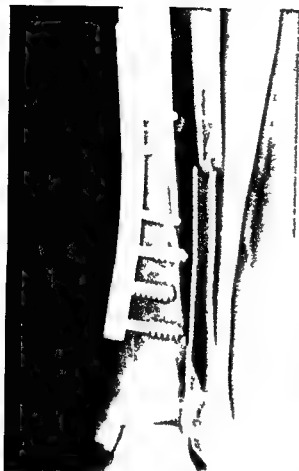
Case 1 Postoperative roentgenogram
